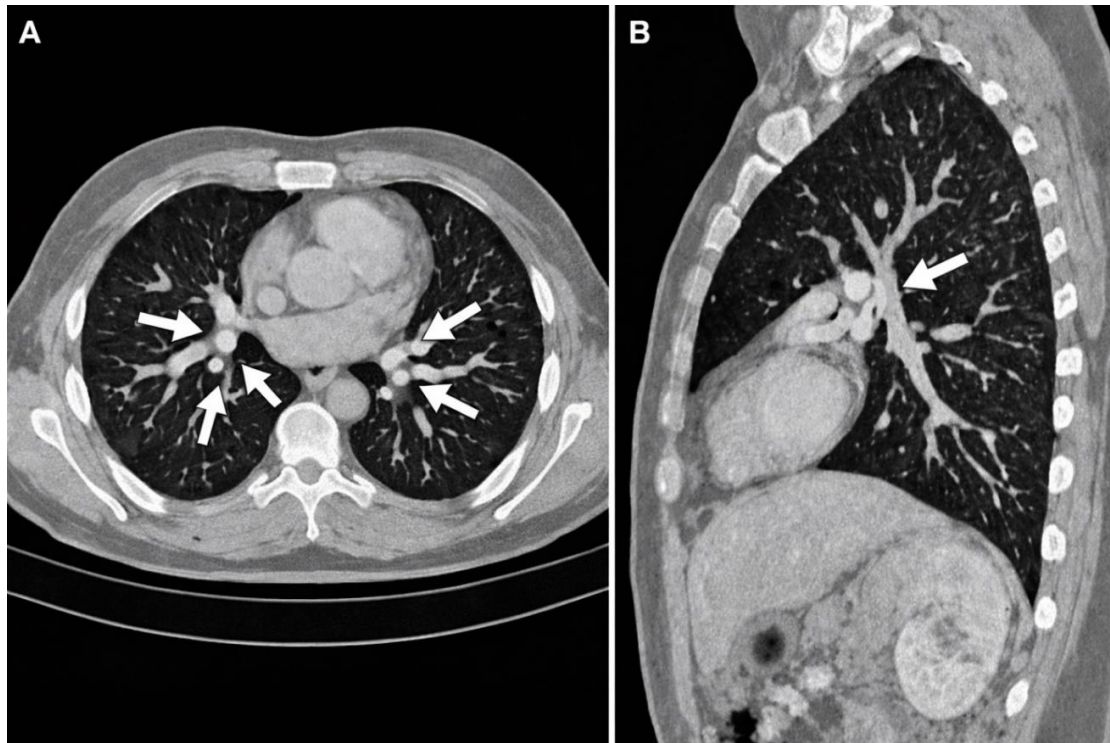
Images of computed tomography pulmonary angiography; A. Axial computed tomography pulmonary angiography (CTPA) demonstrating bilateral subsegmental pulmonary emboli (white arrows). B. Sagittal reconstruction confirming a left subsegmental pulmonary embolus (white arrow)."
